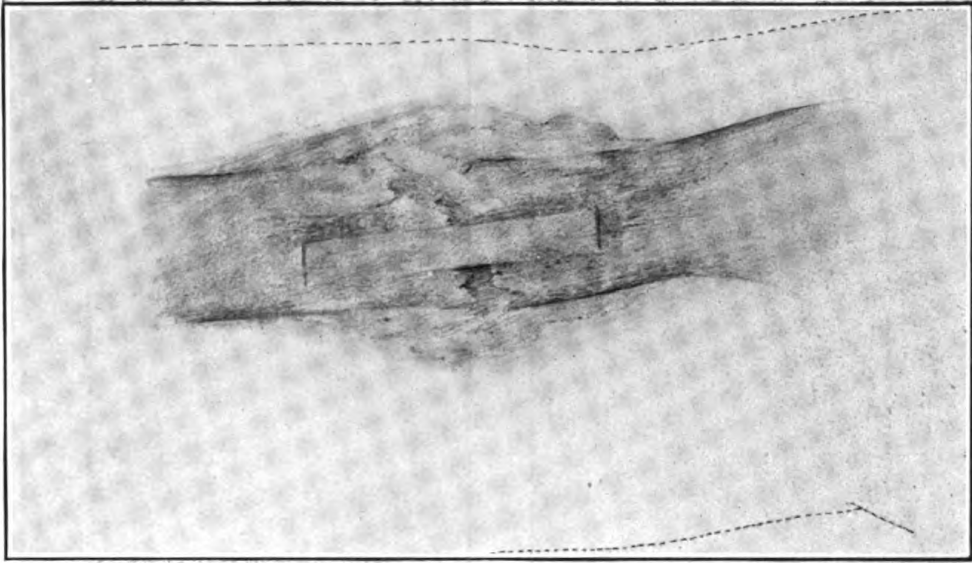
Drawn from X-ray plate. Shows final result in Case 1 after 8 weeks.
